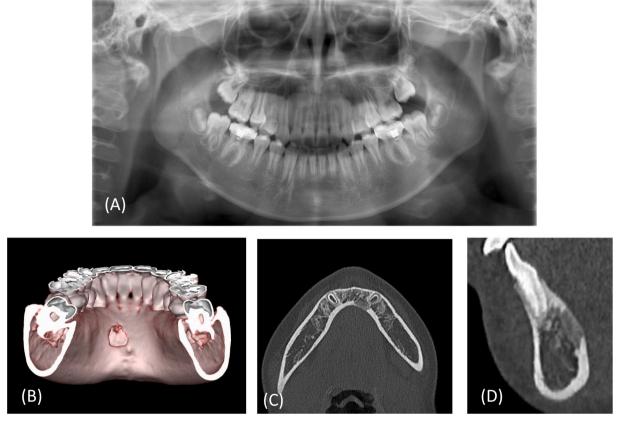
(A) Panoramic radiograph taken during his initial visit. There were no indications suggesting that the lesion was a tumor. (B) 3DCT imagery revealed a $6 \times 5 \times 3$ mm oval shaped defect on the lingual cortical bone at the apex of the mandibular left lateral incisor. (C) (D) showing a lingual cortical bone defect at left lateral incisor.
